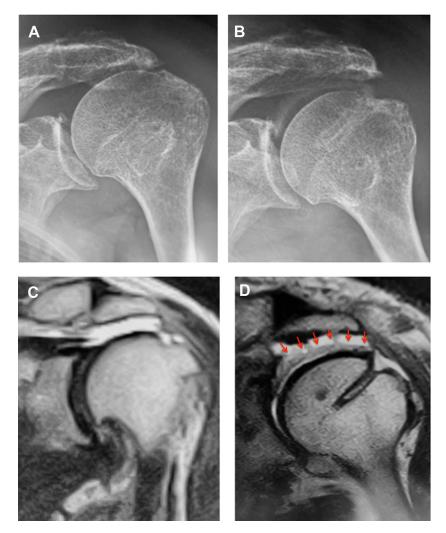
X-ray and T2-weighted magnetic resonance imaging (MRI) findings before and after arthroscopic superior capsule reconstruction (SCR) using a 1-layer Teflon felt graft. (A) X-ray before surgery. (B) X-ray 1 year after SCR. (C) Coronal MRI image before surgery. The torn supraspinatus tendon is severely retracted, and the supraspinatus muscle is severely atrophied. (D) Coronal MRI image 1 year after SCR. \rightarrow show the single-layer Teflon felt graft.
